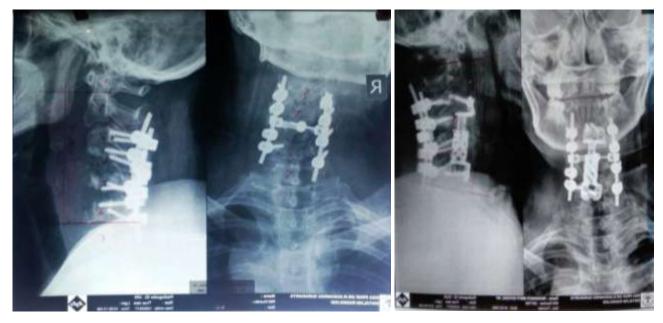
Cervical X-Ray post Anterior Debridement and Posterior Stabilization
